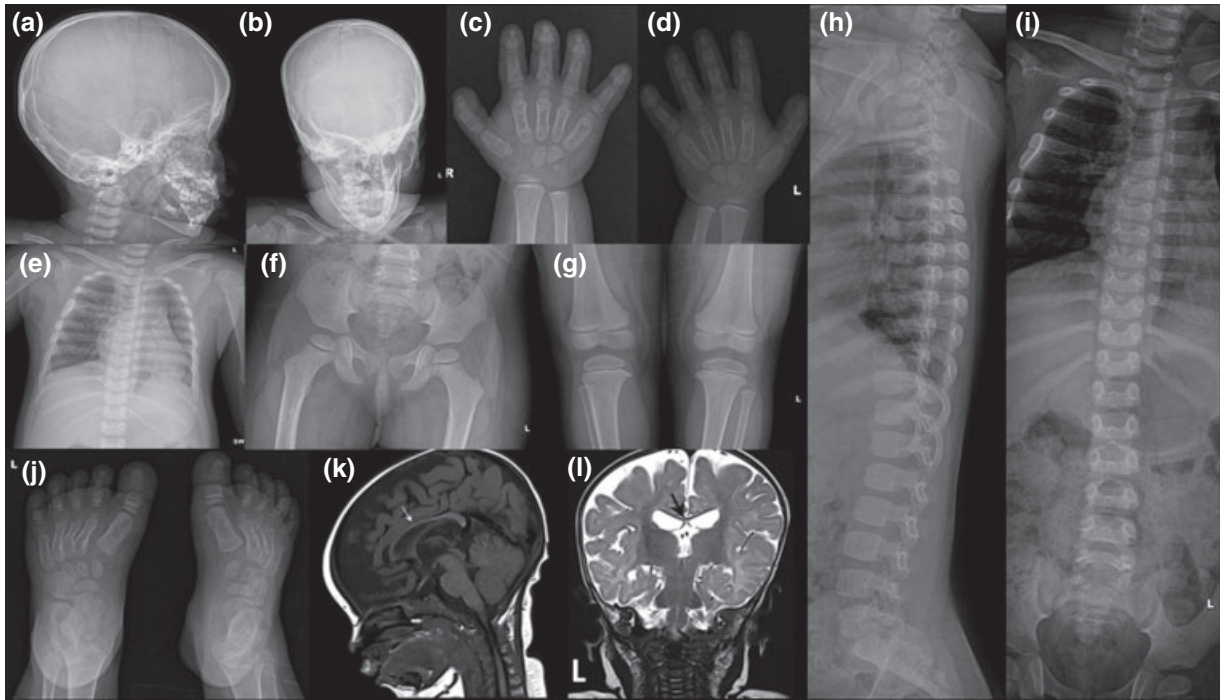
Skeletal survey at age 3 years reveals an unremarkable skull (a, b), short and stubby metacarpals and phalanges, cone-shaped epiphysis of phalanges, hypoplastic distal phalanges and angel-shaped middle phalanges (c, d). Pelvis, hip joints, knee joints and lumbar vertebrae are unremarkable (f–i) and short metatarsals and phalanges in feet (j). Magnetic resonance imaging of the brain at 6 months of age shows hypoplastic corpus callosum (arrows; k, l).
